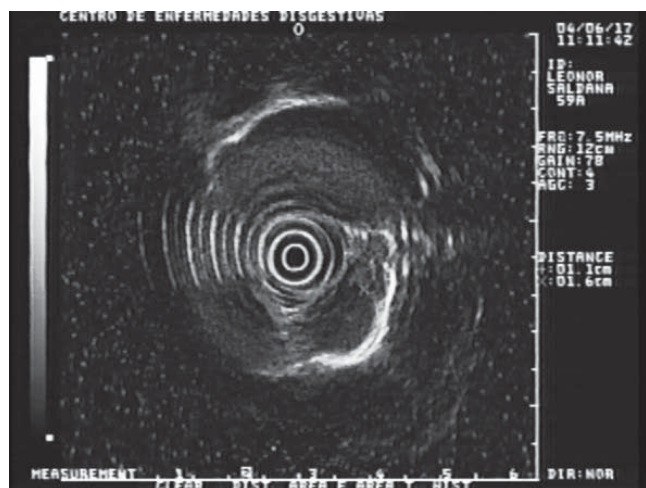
This radial endoscopic sonography shows metastasis in a female patient with breast cancer. The lesion is located between the left frontal auricula and the posterior descending aorta.
